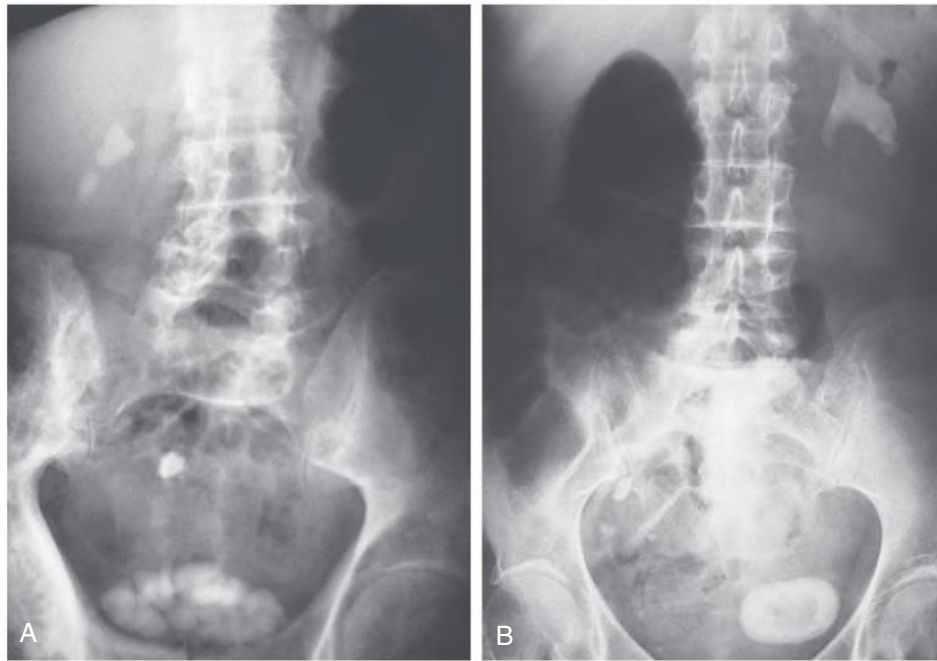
Radiopaque Kidney Calculi. (A) Radiograph showing multiple cystine stones in the right kidney, right ureter, and bladder. (B) Struvite stones: left staghorn calculus and a single bladder stone.
